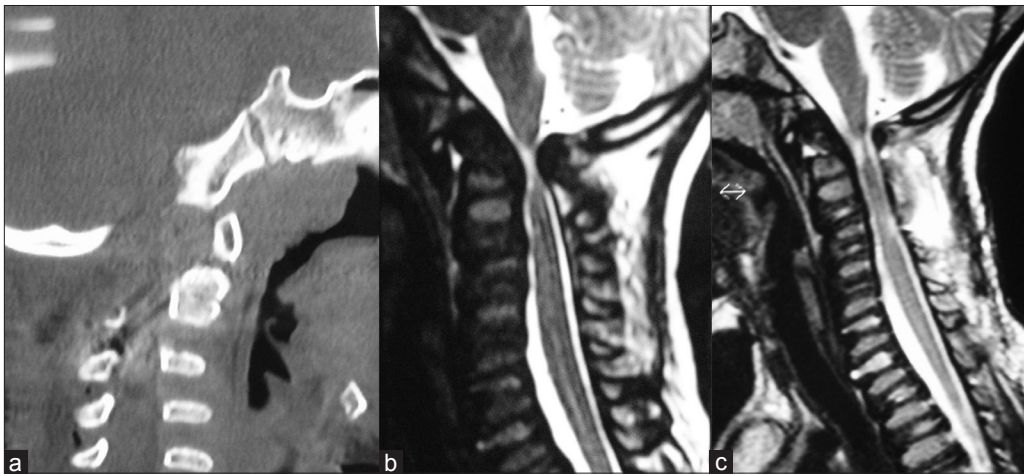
(a) Mid-sagittal CT image showing odontoid hypoplasia (b) Preoperative MR image showing the wafer-thin spinal cord at the craniocervical junction due to the atlantoaxial subluxation (c) Postoperative MR image showing adequate decompression of the spinal cord
